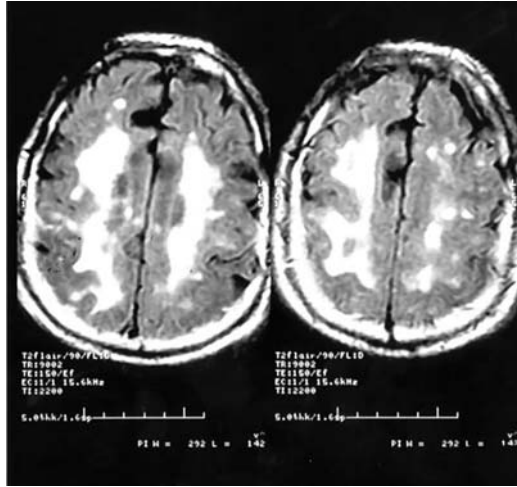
Pronounced subcortical hyperintensities in the subcortical white matter, specifically the centrum semiovale, in a patient with progressive gait and cognitive impairment. This is a FLAIR (transaxial) MRI brain scan with two adjacent sections.
